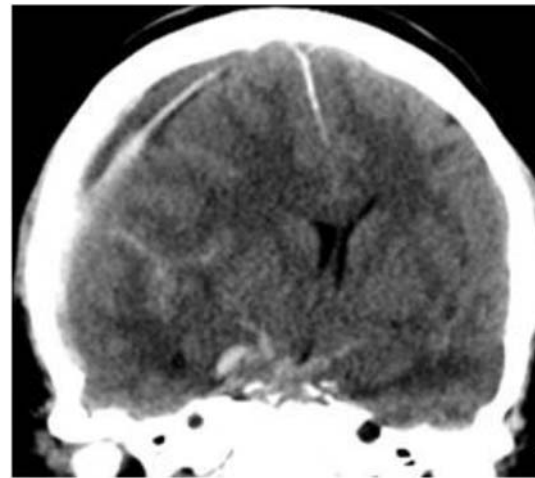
CT angiography that shows acute subdural hematoma and aSAH.
